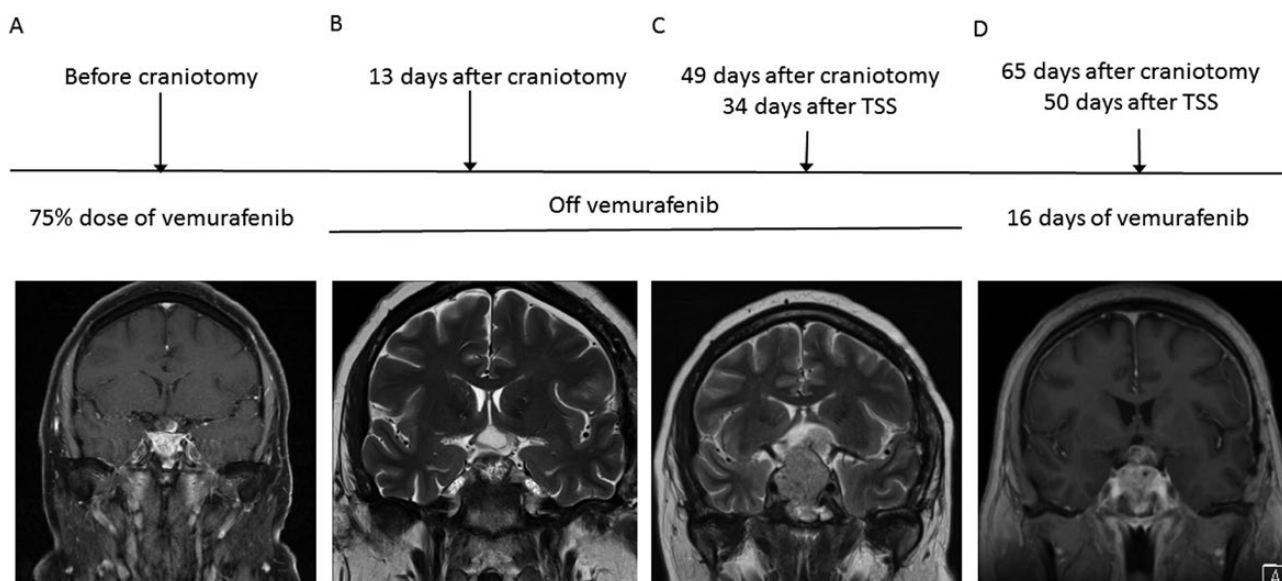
MRI scans before and after his craniotomy followed by his 5th transsphenoidal surgery and treatment with vemurafenib. A: MRI scan demonstrating tumor regrowth, more cystic than solid by the optic apparatus while on a 75% dose of vemurafenib. B: MRI scan 13 days after a craniotomy that showed partial tumor resection. C: MRI scan 34 days after his 5th transsphenoidal surgery that showed rapid tumor regrowth while off treatment with vemurafenib. D: MRI scan after 16 days treatment with full dose vemurafenib, and there was a 55% reduction in tumor size. Abbreviations: MRI, Magnetic resonance imaging; TSS, transsphenoidal surgery.
